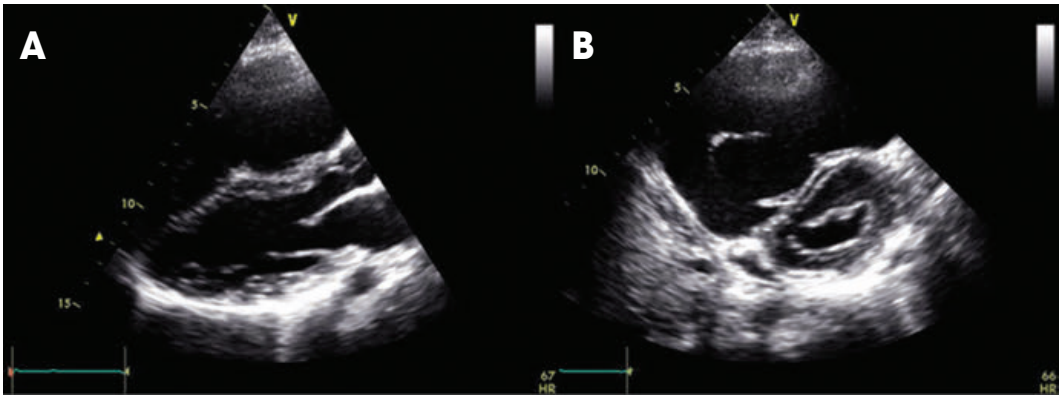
Parasternal long (A) and short axis (B) views showing massive right ventricular (RV) dilatation.
